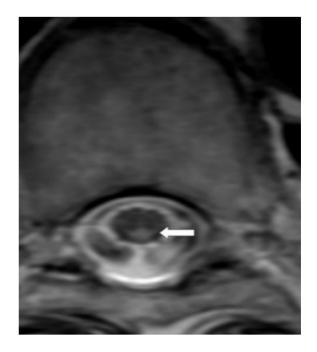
Axial T1 Weighted MRI Image of Thoracic Vertebra which shows no abnormality
